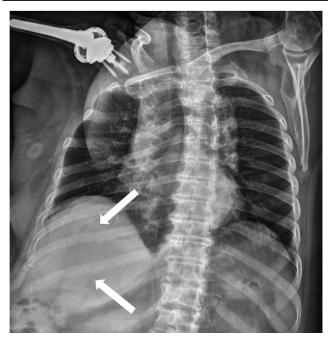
Plain radiograph of the rib cage showing right-sided fracture of the ninth and tenth ribs.
